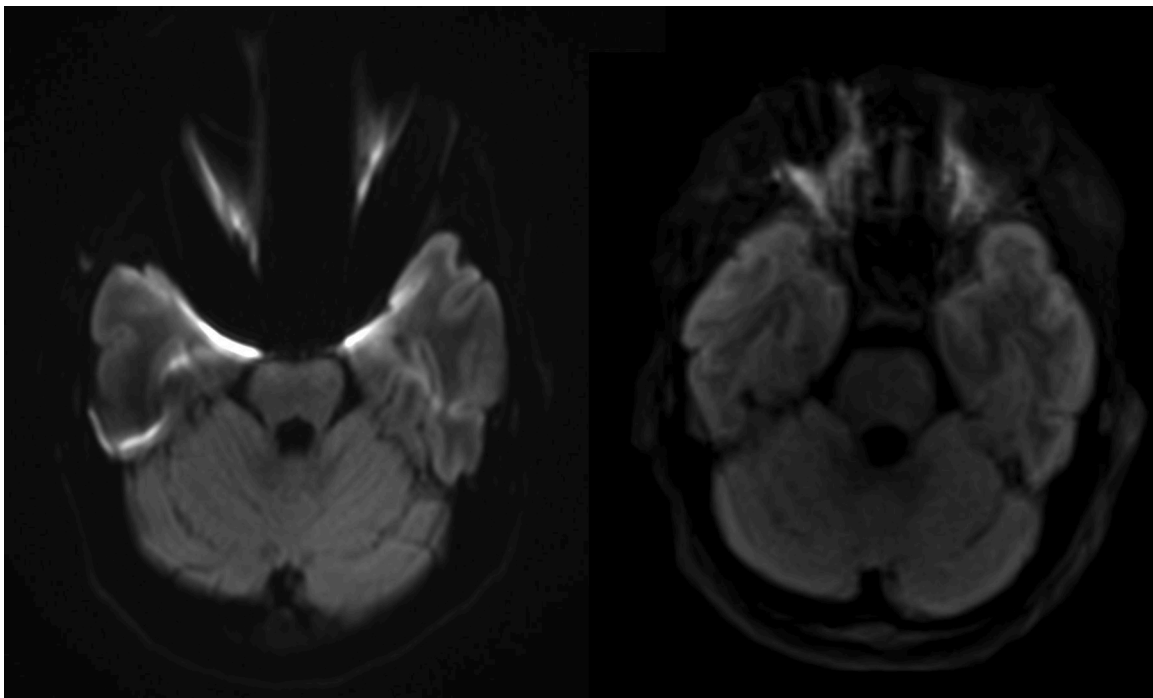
Axial EPI-DWI ( $b = 1000\text{s/mm}^2$ ) (left) and STEAM-DWI ( $b = 1000\text{s/mm}^2$ ) (right), susceptibility artifacts of metallic braces, which limit the assessment of temporal lobes and brain stem.
